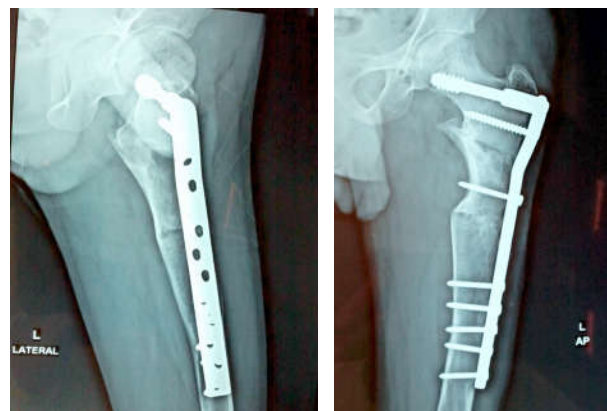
Post operative radiograph at 6 months follow up
